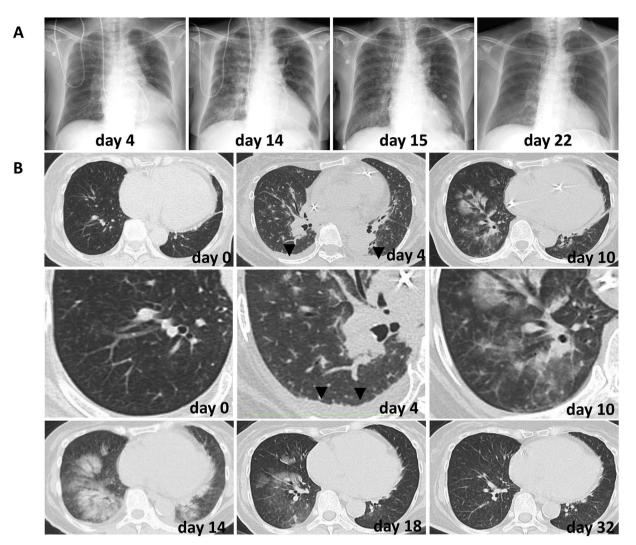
A: In chest X-ray, pulmonary edema worsening from day 4 to day 14 in spite of reduced cardiomegaly, which improved by steroid at day 15. B: A chest CT-scan at day 0 is within normal limit. Multiple ground glass opacities (GGO) and pleural effusion (PE: ♥) emerged from day 4. Regardless PE improvement, GGO without inter-lobular septal thickening became worse from day 10–14. Intravenous prednisolone pulse (1000 mg/day for 3 days) improved GGO at day 18 to normal limit (day 32).
